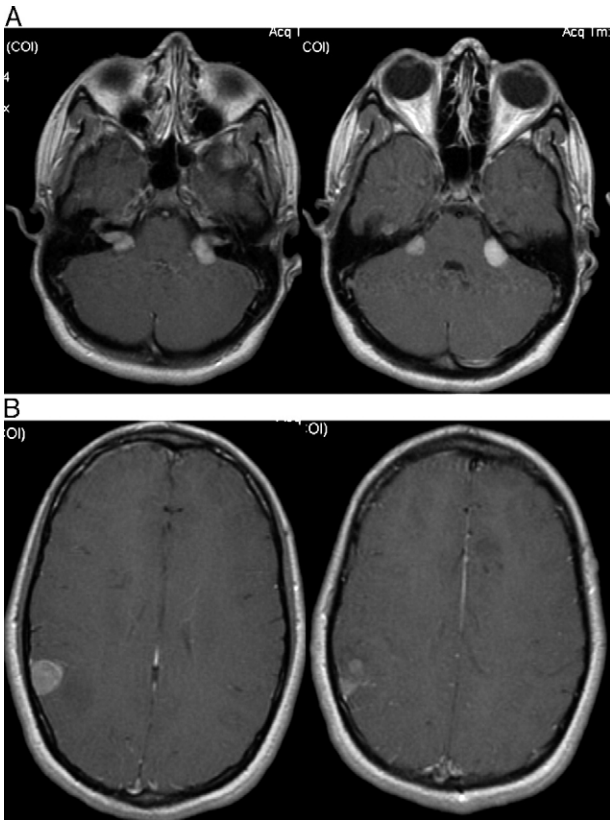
Preoperative axial T1-weighted MRI scans with gadolinium of patient 2 showing (A) bilateral acoustic neuromas and (B) the right temporal-parietal lesion and the left frontal lesion.
